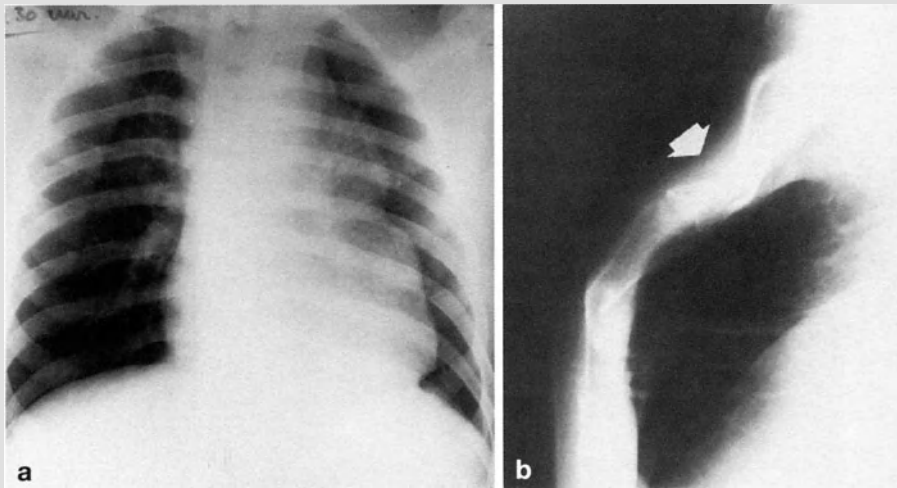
Anterior mediastinal hematoma. a Large anterior mediastinal hematoma, with typical undulating contour. The aortic arch was normal at angiography. b Lateral chest X-ray shows sternal fracture (*arrow*)
